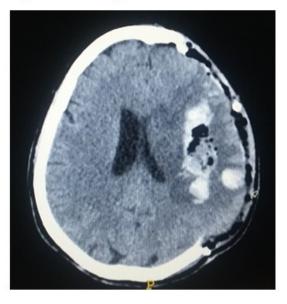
CT scan after bifrontotemporal decompressive craniectomy.
